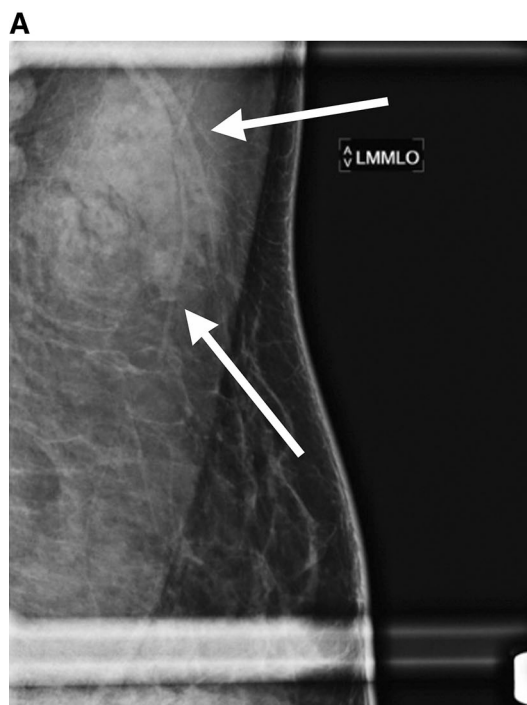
Imaging appearance of benign axillary accessory breast tissue on a mammography and b targeted ultrasound in a lactating patient
